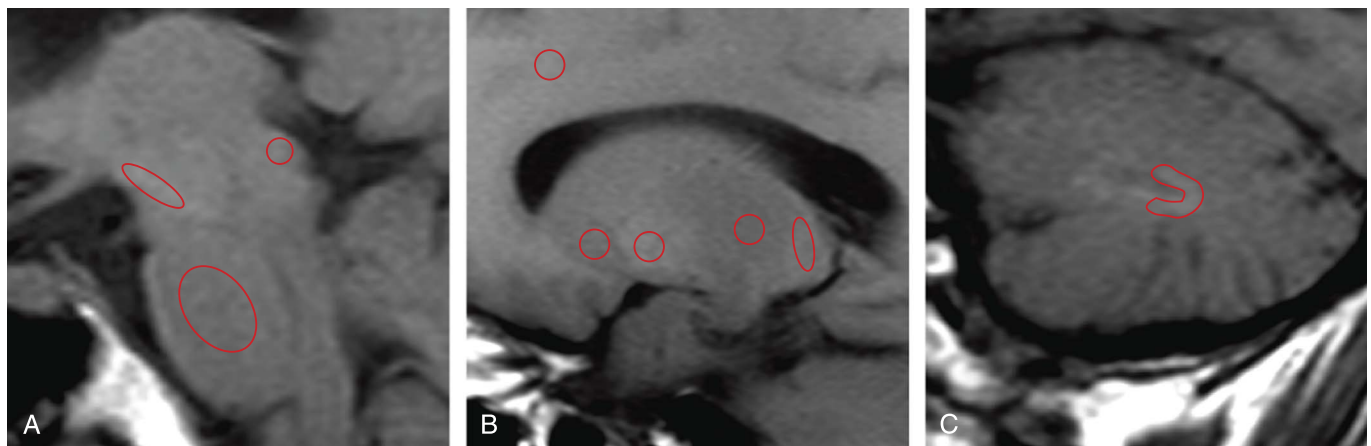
Placement of the ROIs. Three sagittal slices show the ROIs on unenhanced T1-weighted spin echo images. The ROIs were placed on (from left to right): (A) substantia nigra, superior colliculus, and pons; (B) white matter of anterior corona radiata, putamen, globus pallidus, ventral posterior nucleus of the thalamus, and pulvinar; and (C) dentate nucleus.
